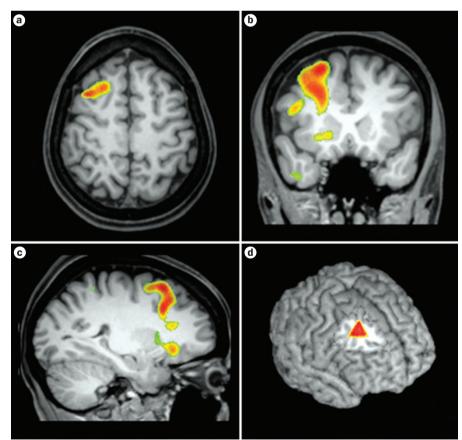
SISCOM can reveal the epileptogenic zone. a | Axial, b | coronal and c | sagittal brain SISCOM images reveal ictal hyperperfusion (red areas) in the right frontal lobe. d | Three-dimensional view showing the area of ictal hyperperfusion (triangle). Abbreviation: SISCOM, computer-aided subtraction ictal single-photon emission CT coregistered to MRI.
